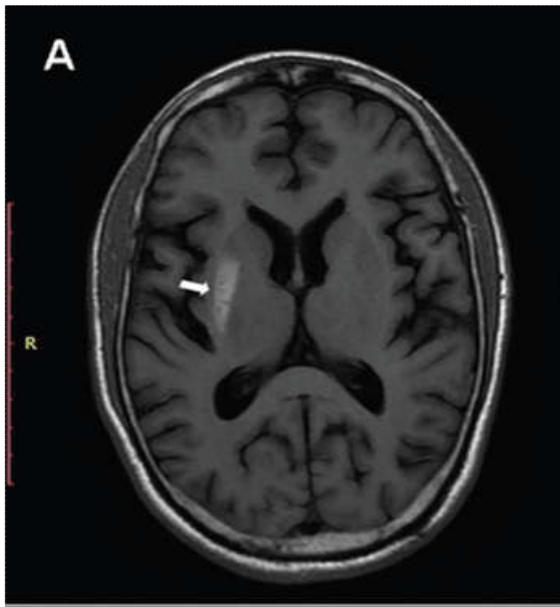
Brain MRI (axial): asymmetric T1 hyperintensity of the left putamen (arrow)
